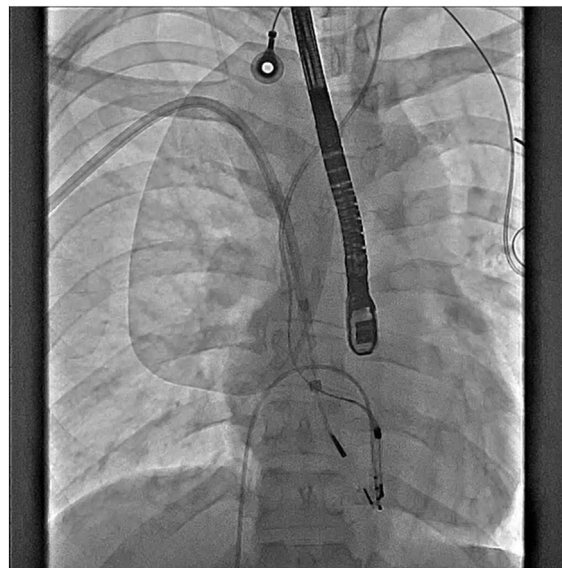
The patient was under general anesthesia. Transesophageal echocardiogram (TEE) was used for intraprocedural monitoring. A laser sheath was inserted via right axillary vein for right sided pacemaker lead.
